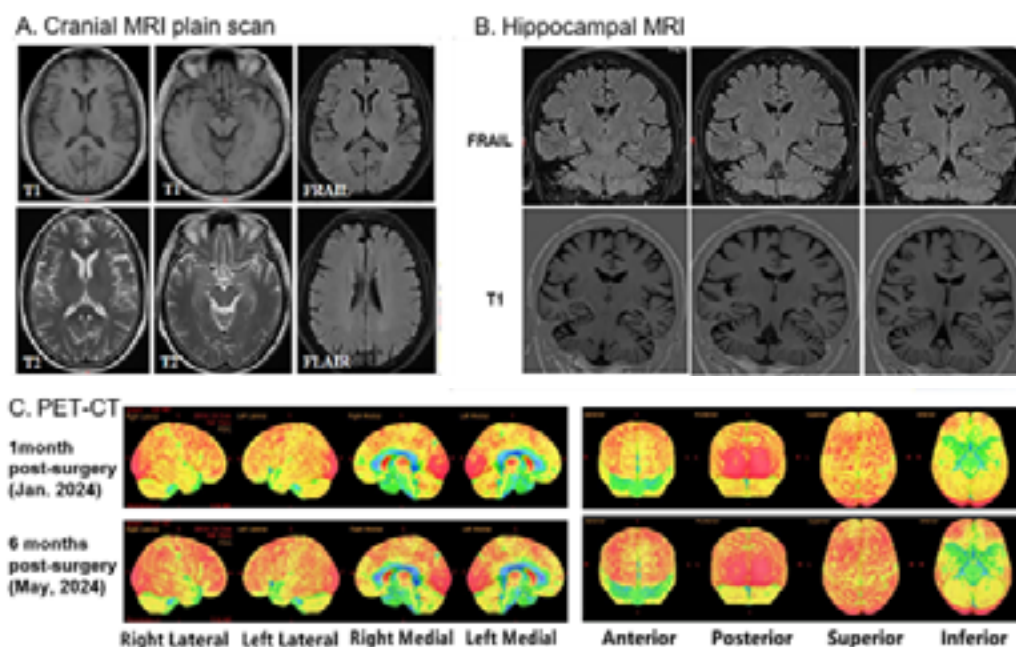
NRI and PET-CT imaging of AD patient brain.
